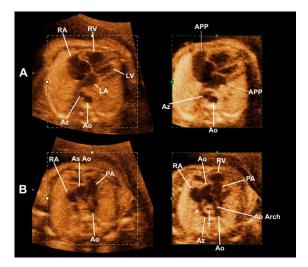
Comparison of minimum projection mode (MPM) images, on the right, with their corresponding two-dimensional images, on the left, in a case of left isomerism with interrupted IVC and azygos continuation. A) The four-chamber view shows a two-vessel sign; the MPM image shows that both atria appendages (APP) are morphologically left; B) Three-vessel view. In the MPM image, the azygos vein drains into the superior vena cava (SVC) and the right atrium, whereas the two-dimensional ultrasound image shows only the ascending aorta, the pulmonary artery and the dilated right atrium. RA: right atrium, RV: right ventricle; LV: left ventricle; LA left atrium, Ao: aorta; AZ: Azygos vein; PA: pulmonary artery; Ao Arch: aortic arch, T: trachea, \*: Azygos' arch
